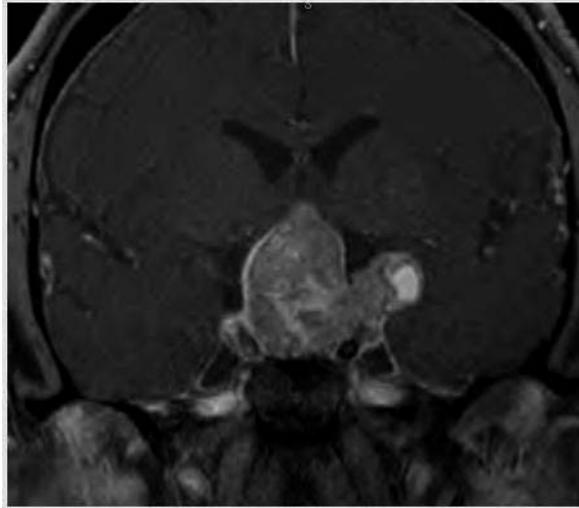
Coronal MRI of a patient with a large pituitary mass compressing the optic chiasm causing bitemporal hemianopsia.
